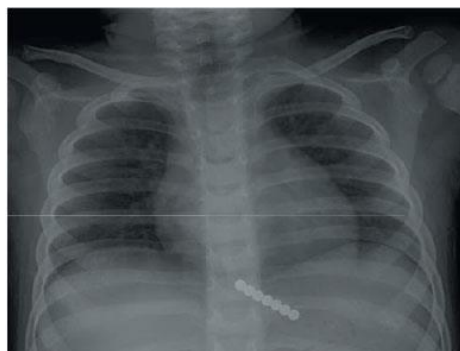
X-ray image of a 3-year-old child with a set of magnets lodged in his gastro-intestinal tract.
